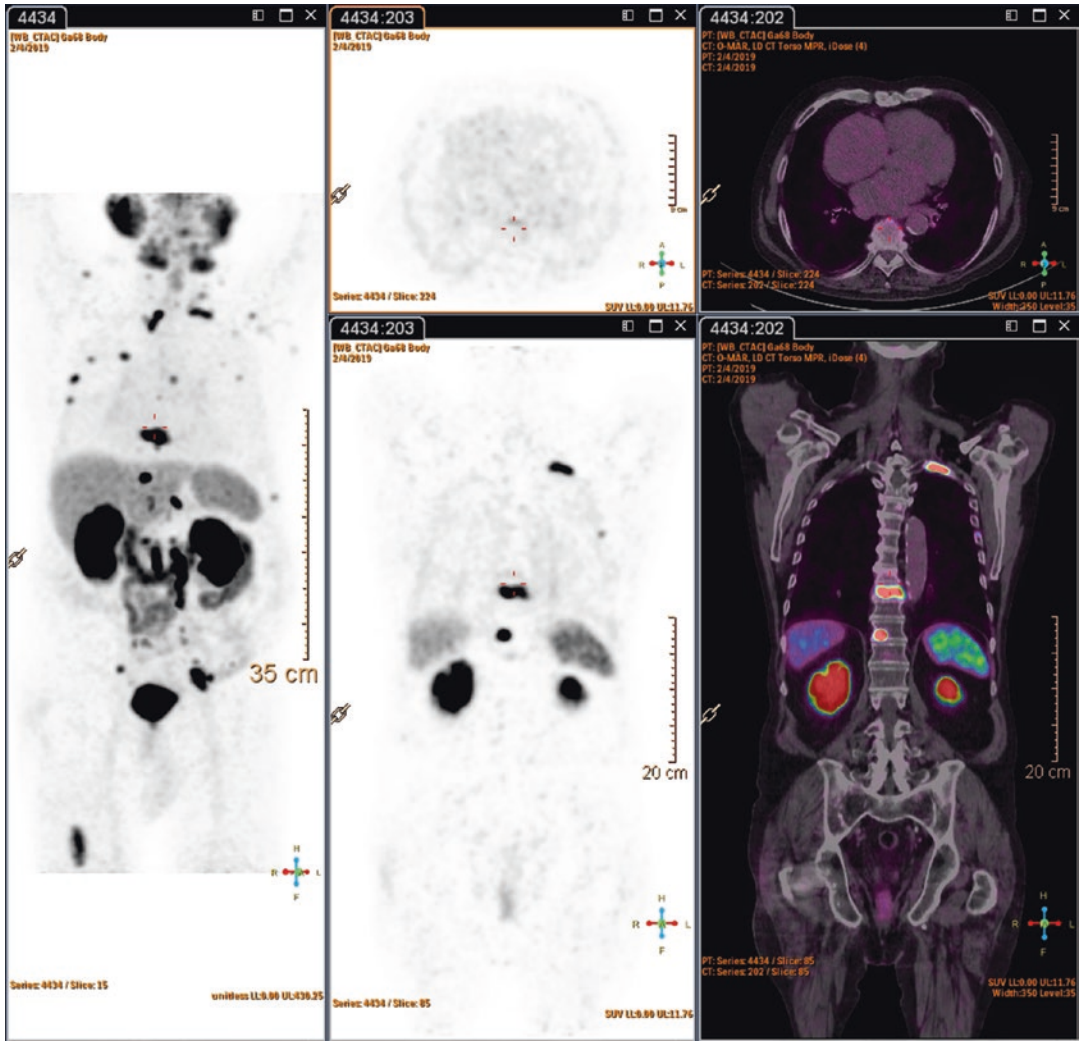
Massive osseous metastasis is presented here by ⁶⁸Ga-PSMA, some positive lymph node metastases were observed as well
